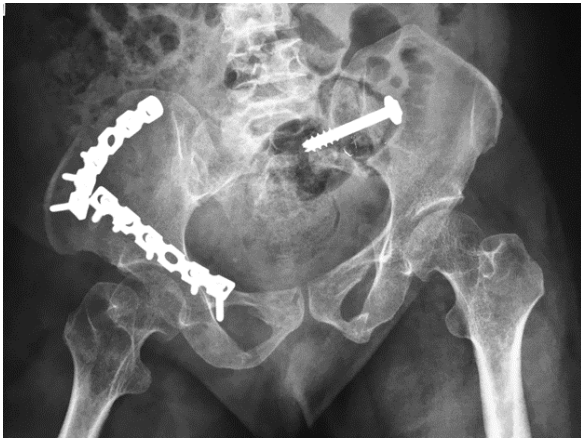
Post-operative radiograph showing plates and screws using for internal fixation of the fractured components of the pelvis.
